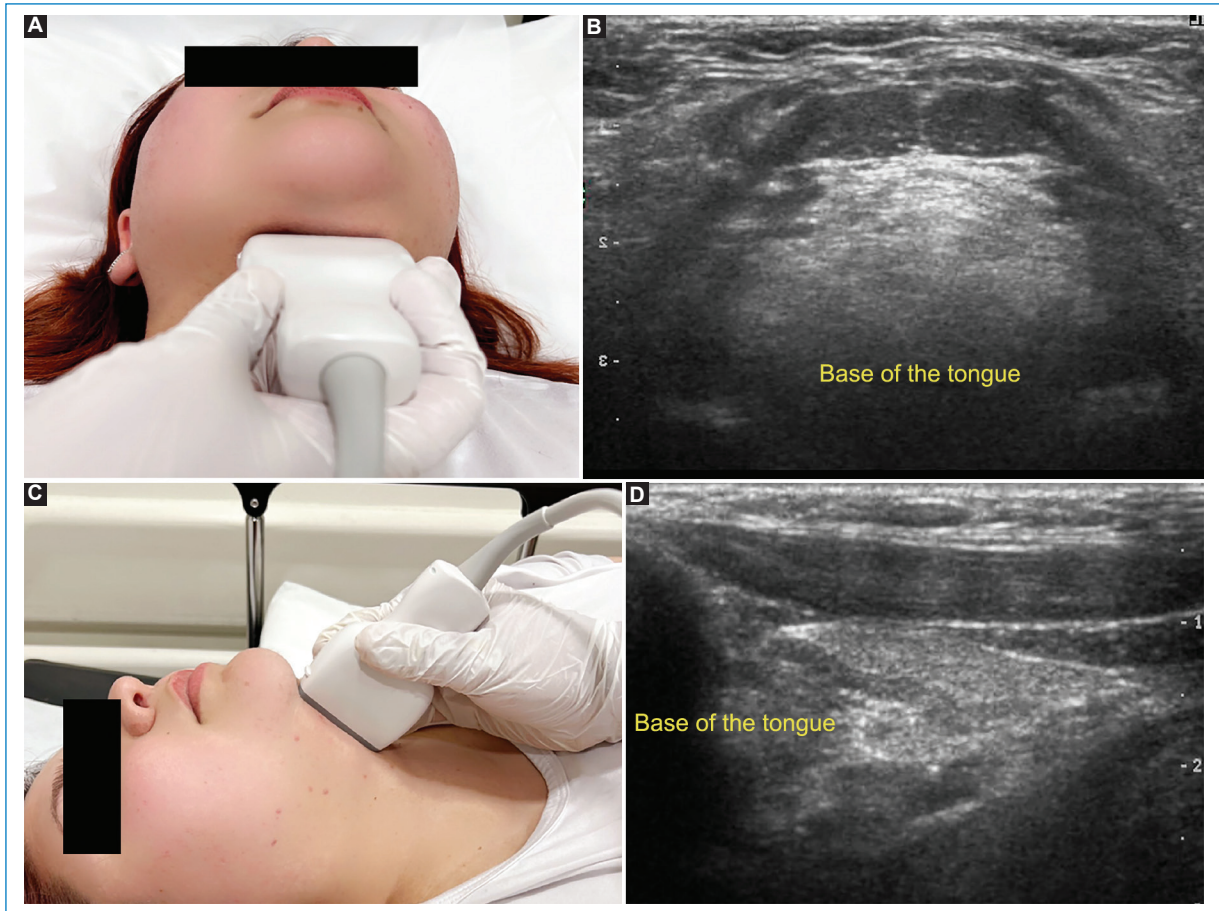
Example of a submandibular approach with an 11 MHz transducer. The transducer is shown positioned transversely on a patient (A) with the respective ultrasound image (B), and also positioned longitudinally (C) with its ultrasound representation (D).
